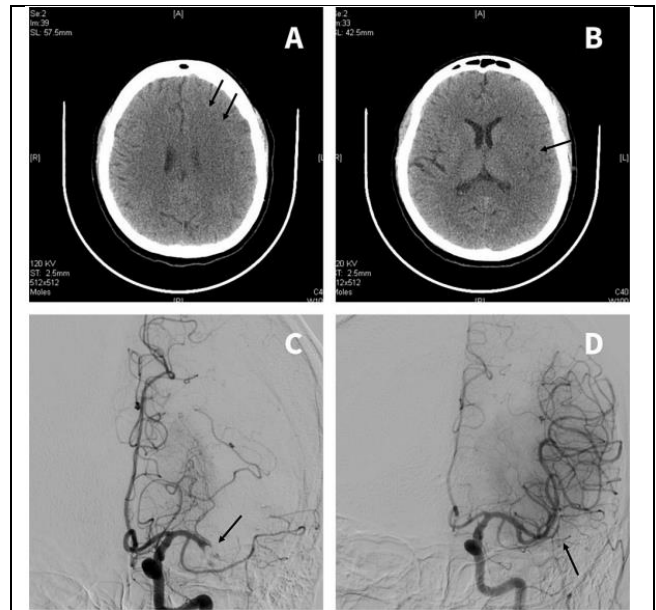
Intracranial imaging. A plain head computed tomography scan shows decreased attenuation of the grey-white matter junction in the left frontal lobe (black arrows) (A), the left insular area (black arrow) (B); CT angiography shows blockage of the left middle cerebral artery in the proximal M1 segment (black arrow) (C) and effective reperfusion (black arrow) and a TICI score of 2b (D).
